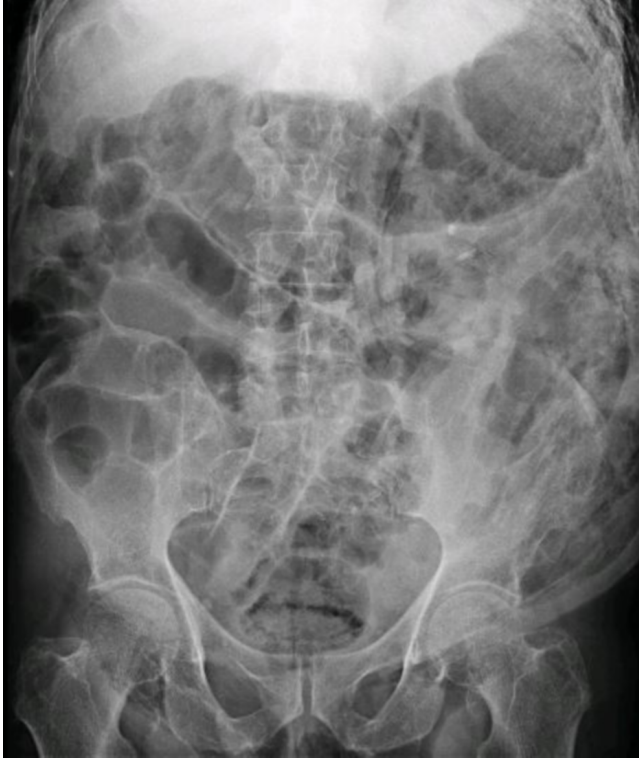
80-year-old man with massive subcutaneous emphysema. Abdominal radiograph shows extensive subcutaneous emphysema of the abdominal wall.
